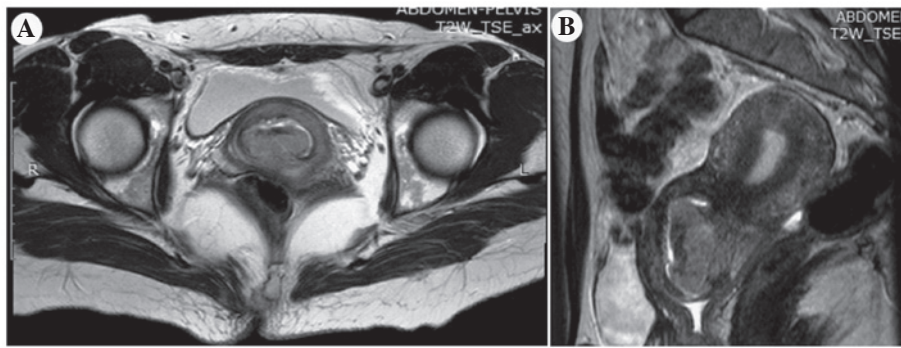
(A and B) A large cervical tumor was identified in the T2 sequence of pelvic magnetic resonance imaging, demonstrating no signs of local invasion.
